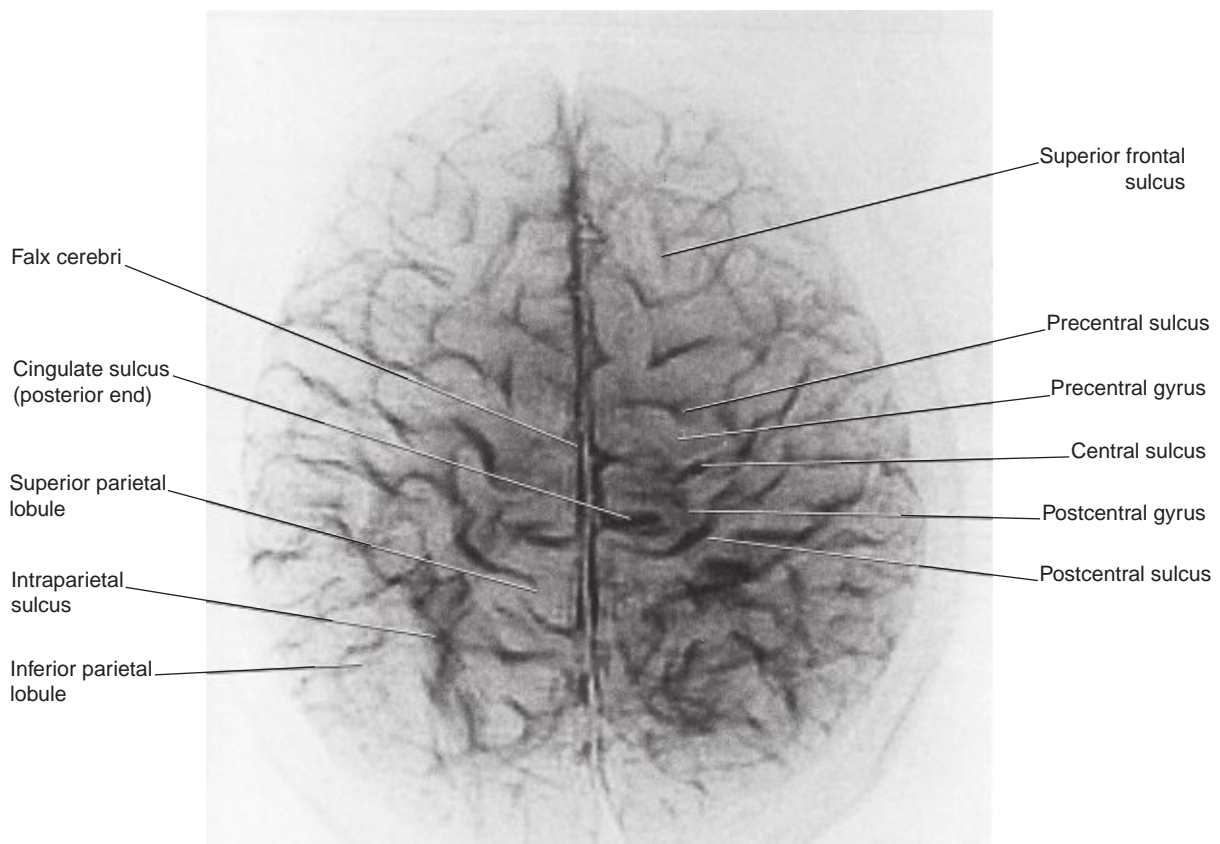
'Thick slice' surface anatomy brain MRI scan from a healthy volunteer. (From Katada, 1990.)
